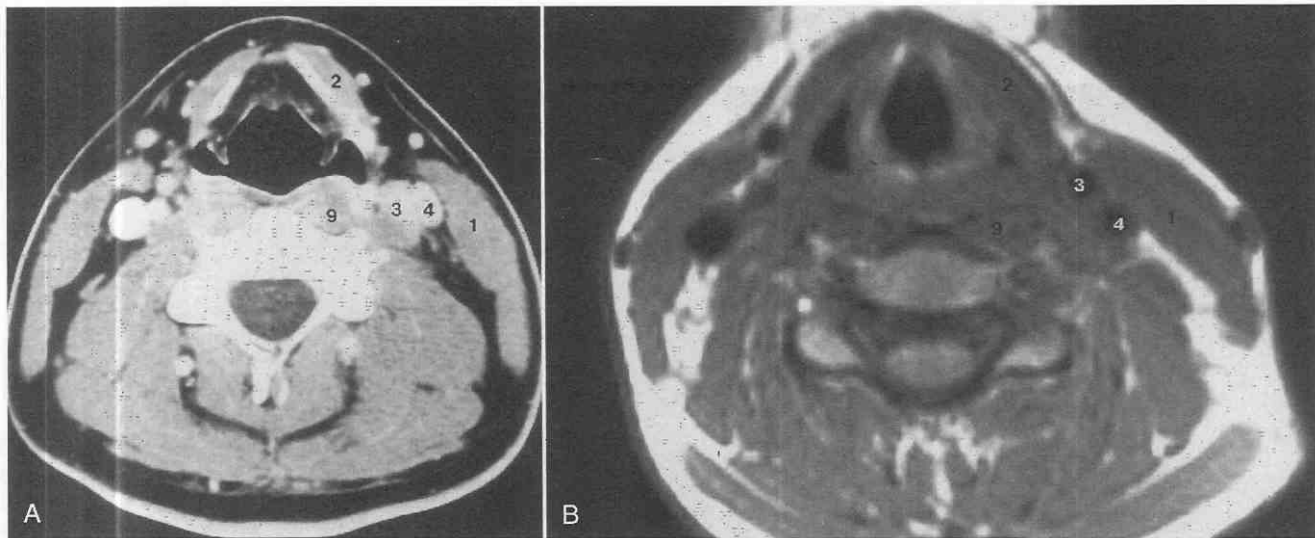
Normal axial anatomy at the level of the thyroid cartilages. *A*, CT scan. *B*, T1-weighted MR image. Note how the anterior margin of the sternocleidomastoid muscle is located anterior to the vertebral body. Compare with Figure 17-2*B*. 1, Sternocleidomastoid muscle; 2, strap muscle; 3, internal carotid artery; 4, internal jugular vein; 9, longus colli muscle.
